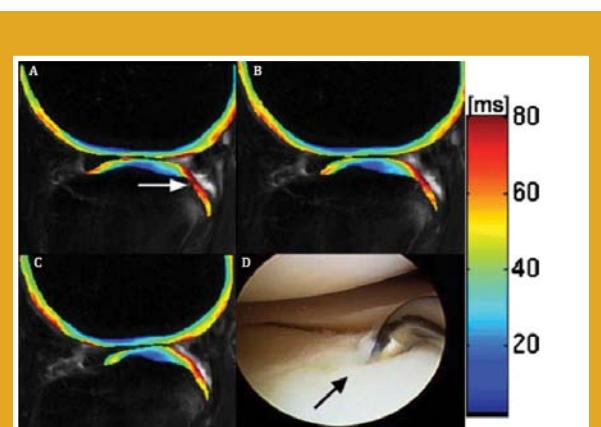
A, B, and C shows a color-coded $T_{1\rho}$ map overlaid on 3-T magnetic resonance images, demonstrating the increased $T_{1\rho}$ relaxation times along the posterolateral aspect of the tibial plateau at the site of the tibial plateau bone bruise (white arrow). The mean $T_{1\rho}$ value of the cartilage directly over the bone bruise was 60.2 ± 13.7 ms, whereas the mean $T_{1\rho}$ value of the remaining cartilage was 37.5 ± 14.3 ms. D is an arthroscopic image demonstrating Outerbridge grade-1 softening of the articular cartilage overlaying the posterolateral aspect of the tibial plateau with a focal area of grade-2 fissures in the region of the bone bruise (black arrow).
